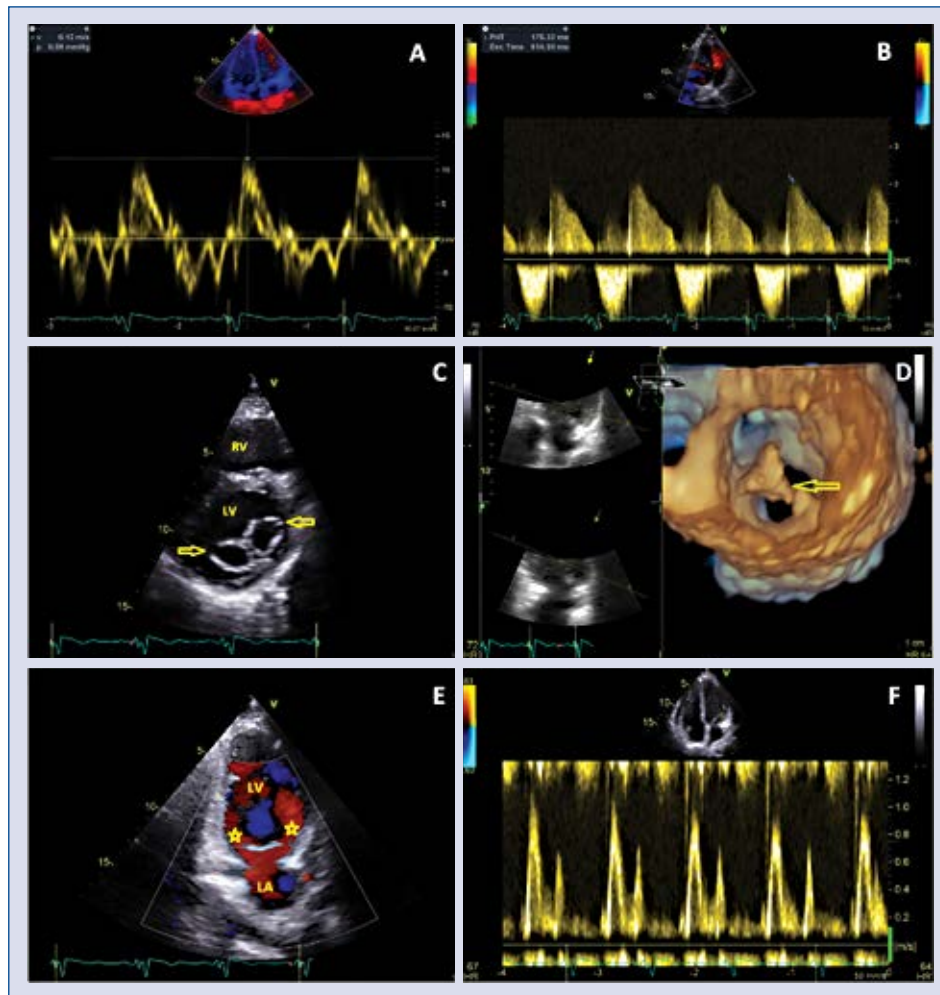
Two-dimensional and three-dimensional (3D) echocardiographic study of a patient with repaired tetralogy of Fallot and newly diagnosed double-orifice mitral valve. Tissue Doppler imaging in the apical four-chamber view revealed preserved function of the enlarged right ventricle (A). In a parasternal short axis view a color Doppler guided continuous wave regurgitant pulmonary flow of moderate degree was also recorded (B). C. Parasternal short axis view in transthoracic echocardiography. Two separate mitral valve orifices of equal size were observed (arrows). D. Transthoracic 3D image of mitral valve. Mitral valve orifice divided by bridging structure clearly demonstrated at the left ventricular view (arrow). E. Color Doppler flow velocity mapping in an apical view demonstrated two separate jets of left ventricular filling (asterisks). Pulsed wave Doppler imaging confirmed unrestricted opening of the valve (F); LA — left atrium; LV — left ventricle; RV — right ventricle.
